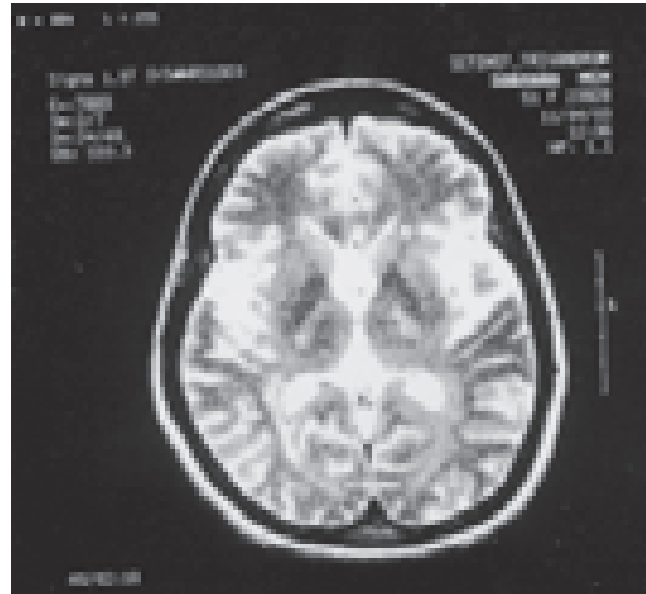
MRI T2 axial image after six months - most of the lesions have disappeared and there are no new lesions.
